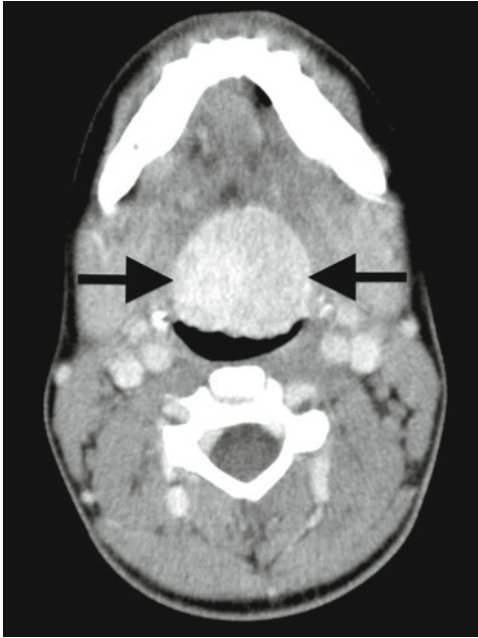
Lingual thyroid. An axial enhanced CT scan through the neck in a young child with hypothyroidism, a long-standing sensation of neck fullness, and tongue mass on radiographs shows a clump of high attenuation thyroid tissue in the base of the tongue, known as a lingual thyroid.
